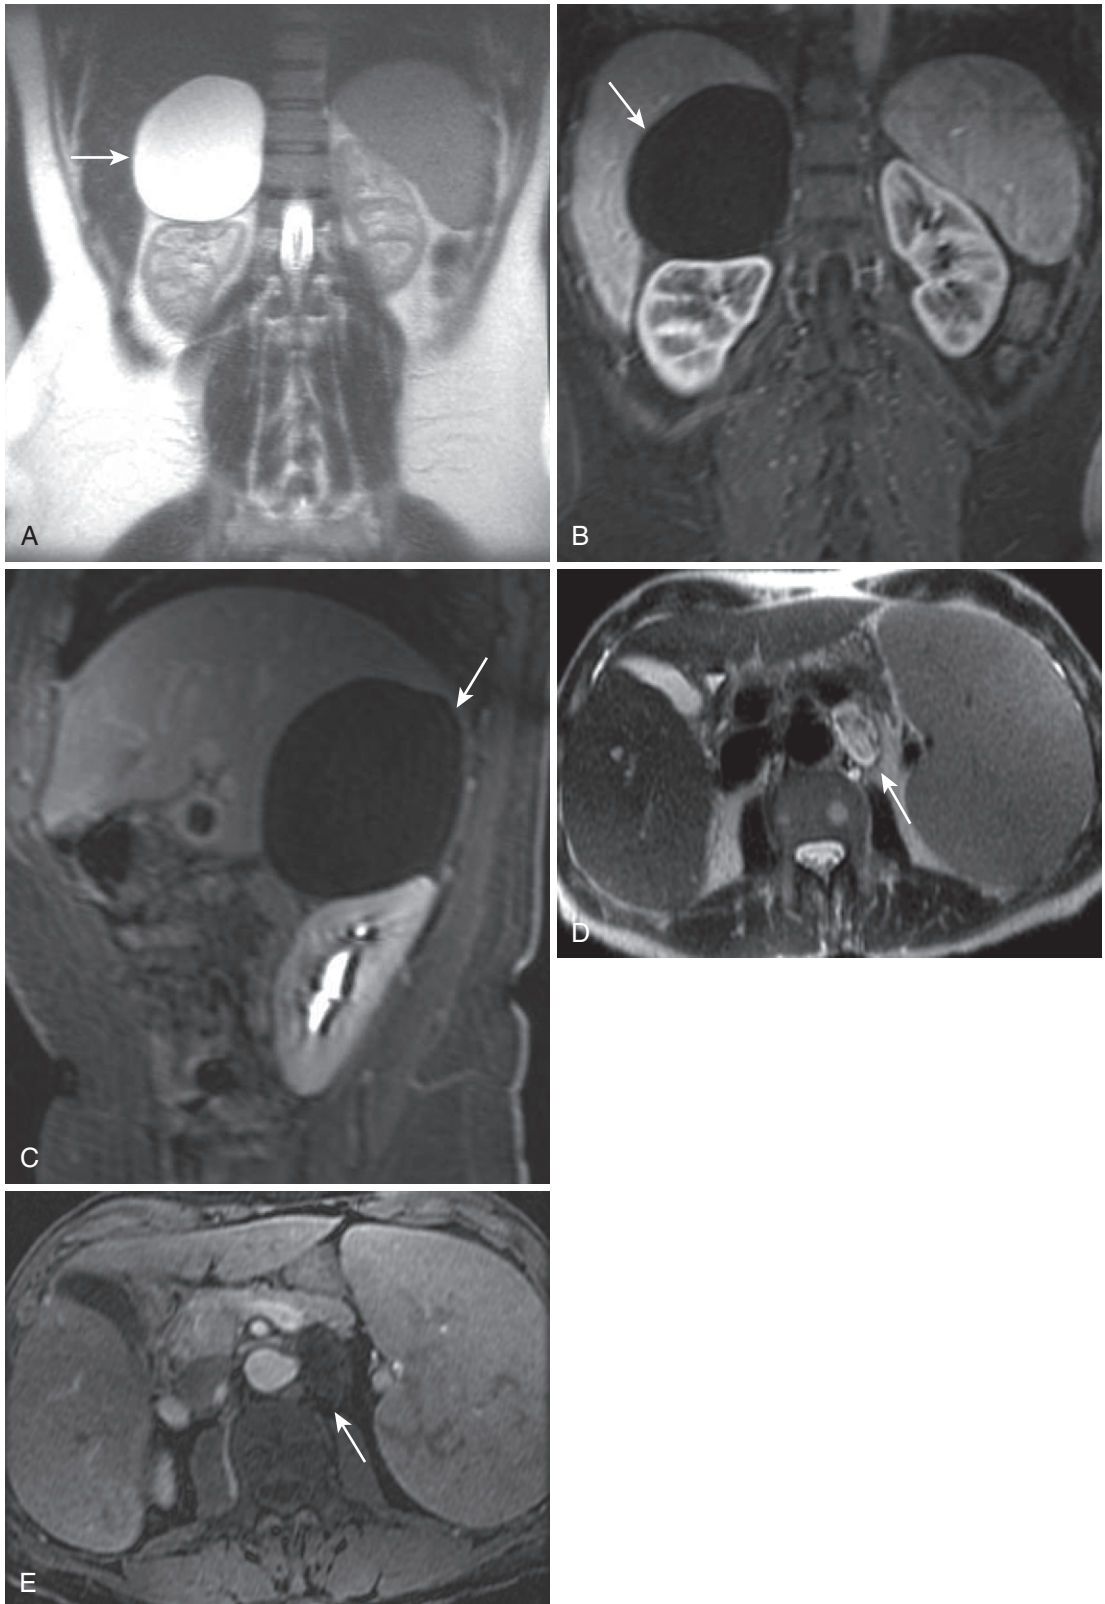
Adrenal cyst. Coronal T2-weighted (A) and enhanced (B) images show a right-sided true adrenal cyst (*arrow*) with simple cystic features. C, The sagittal postcontrast image confirms the extrarenal origin with reciprocally convex margins (*arrow*). A more complex left-sided adrenal pseudocyst (*arrow* in D and E) in a different patient demonstrates internal complexity on the T2-weighted image (D), but no enhancement on the postcontrast image (E).
